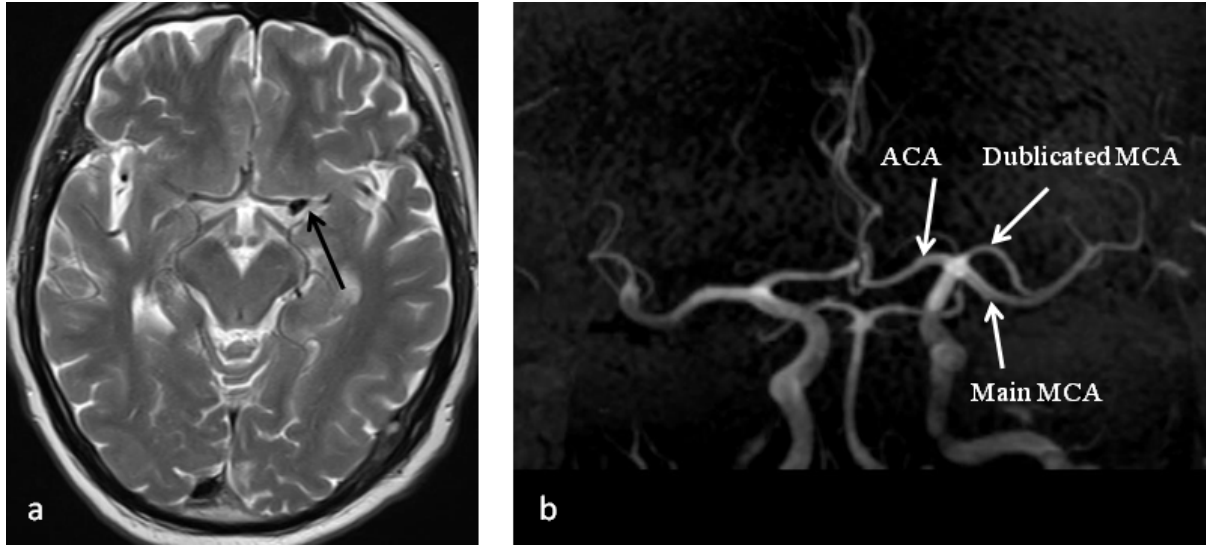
In the axial T2-weighted MRI, extensive vascular segment suggesting an aneurism at the level of left MCA outlet was revealed (a). On the MR angiography, an image of duplicated MCA originating from the distal segment of the left ICA was observed. No aneurism was determined at this level (b).
